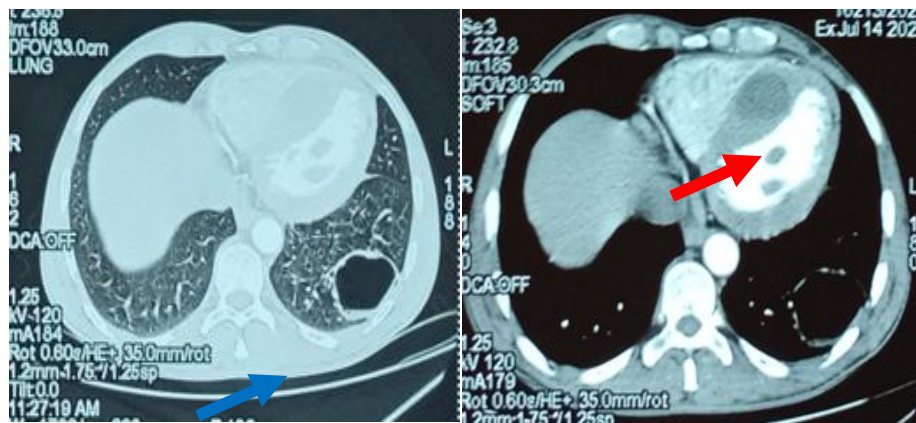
TAP CT scan at the thoracic level: Cross section passing through C5: A-Parenchymal window: Stage I simple right cyst of the lower lobe of the left lung (Blue arrow). B- Bone window: Cystic lesion of the interventricular septum (red arrow)
